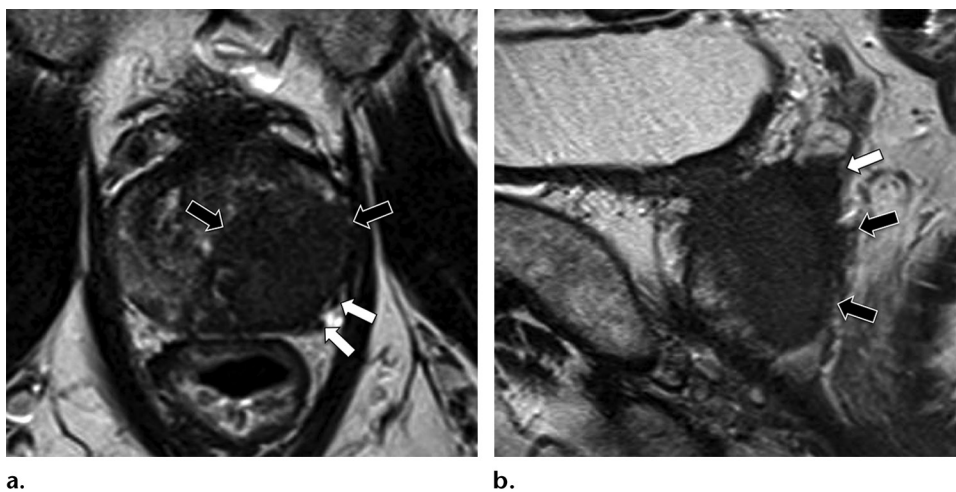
Images of a 58-year-old man with prostate cancer (Gleason score, 5 + 4) detected at systematic transrectal US-guided biopsy, who was referred for multiparametric MR imaging for staging. Axial (a) and sagittal (b) T2-weighted MR images show a 4.3-cm low-signal-intensity irregularly shaped mass (black arrows) diffusely involving the transition and peripheral zones of the left lobe of the prostate, with extraprostatic extension (T2-weighted imaging score: 5). Note the involvement of the ipsilateral neurovascular bundle (white arrows on a), which is asymmetrically thickened compared with the right neurovascular bundle, as well as the invasion of the ipsilateral seminal vesicle (white arrow on b). Because of the extraprostatic extension, this focal lesion was assigned a PI-RADS assessment category of 5, consistent with the biopsy-proven clinically significant cancer in this region.
